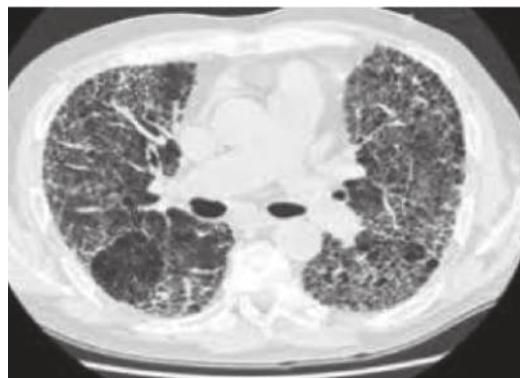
CT findings of interstitial pneumonia in the lungs a patient with systemic sclerosis
